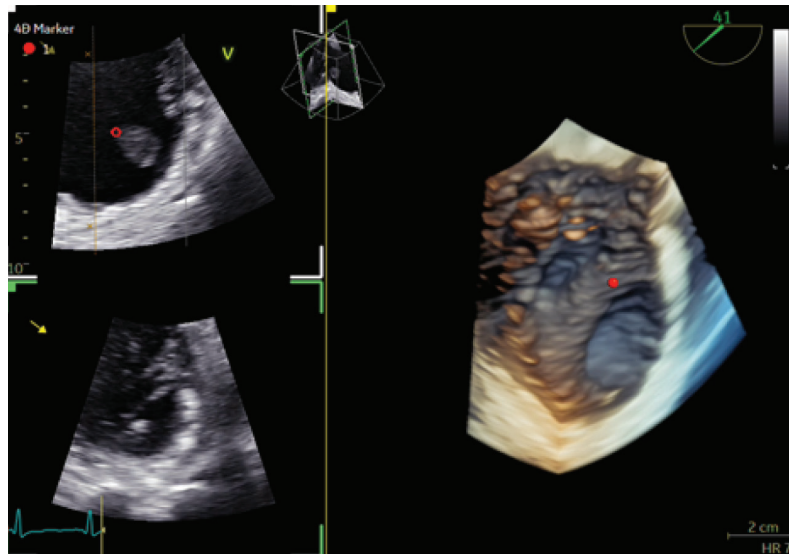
Left ventricular tumor on 4D transesophageal echocardiography.
